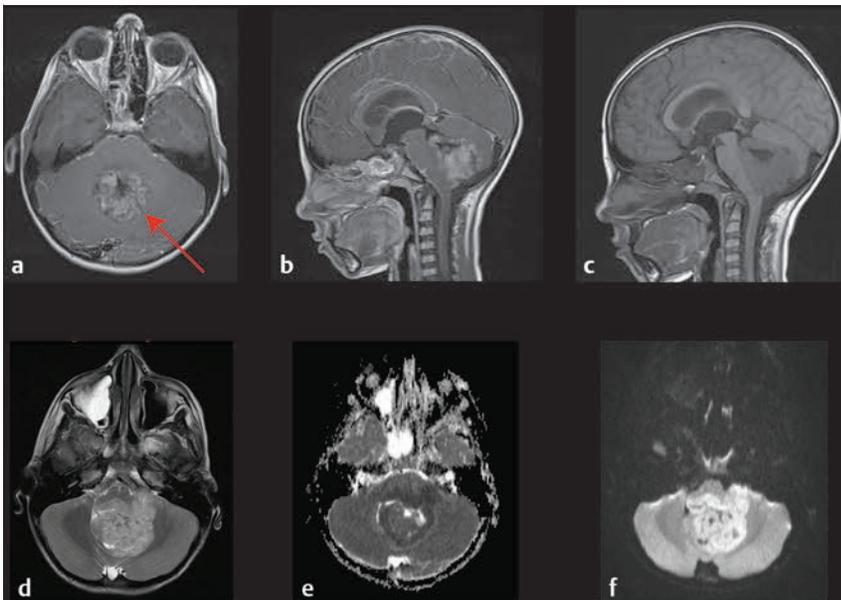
Magnetic resonance (MR) image at diagnosis of a midline medulloblastoma. (a) Axial and (b) sagittal T1-weighted gadolinium-enhanced MR images. Note the homogeneous enhancement following contrast administration. (c) Sagittal T1-weighted unenhanced MR image. (d) Axial T2-weighted MR image (note the peritumoral edema). (e) Axial apparent diffusion coefficient (ADC) map and (f) axial diffusion-weighted Image (b1000). Note the restricted diffusion observed throughout the tumor.
